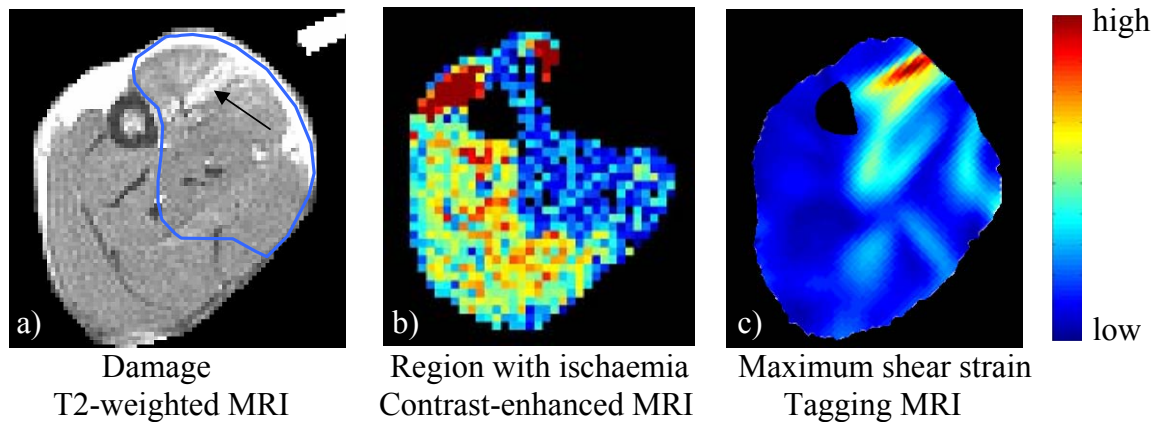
A summary of the findings of the MR measurements in the slice underneath the indenter. a) Location of damage after unloading indicated by increase in T2 (arrow). The blue line indicates the area that appeared to be ischaemic during loading, as measured by contrast-enhanced MRI. b) Perfusion index (PI)-map during loading determined from signal increase after Gd-DPTA injection. c) Distribution of maximum shear strain during loading, as calculated from MR tagging measurements. This was measured in a separate experiment, with indentation values similar to that in a) and b).*
